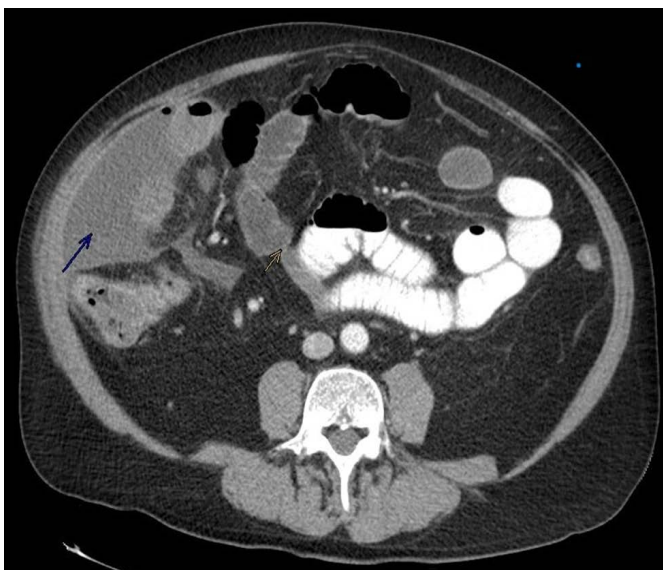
Computed Tomography of Abdomen with contrast. Blue Arrow pointing to layering free fluid foci with apical pockets of air surrounding the ascending colon and yellow arrow pointing to the stricture caused by the cancer.
